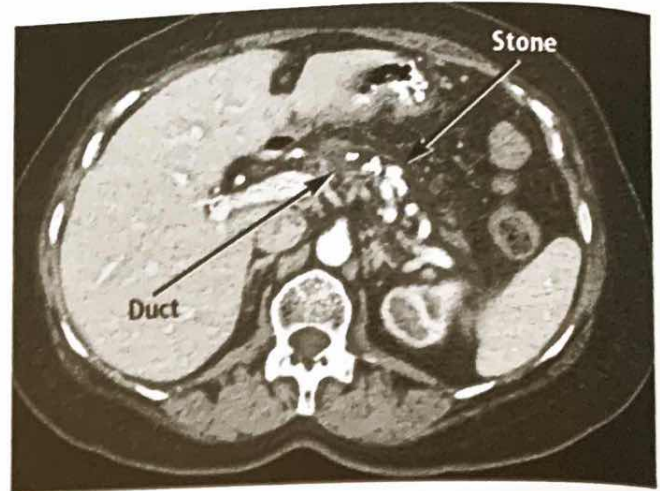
CT scan showing chronic calcific pancreatitis with multiple stones in the main duct and side branches of the pancreas.
